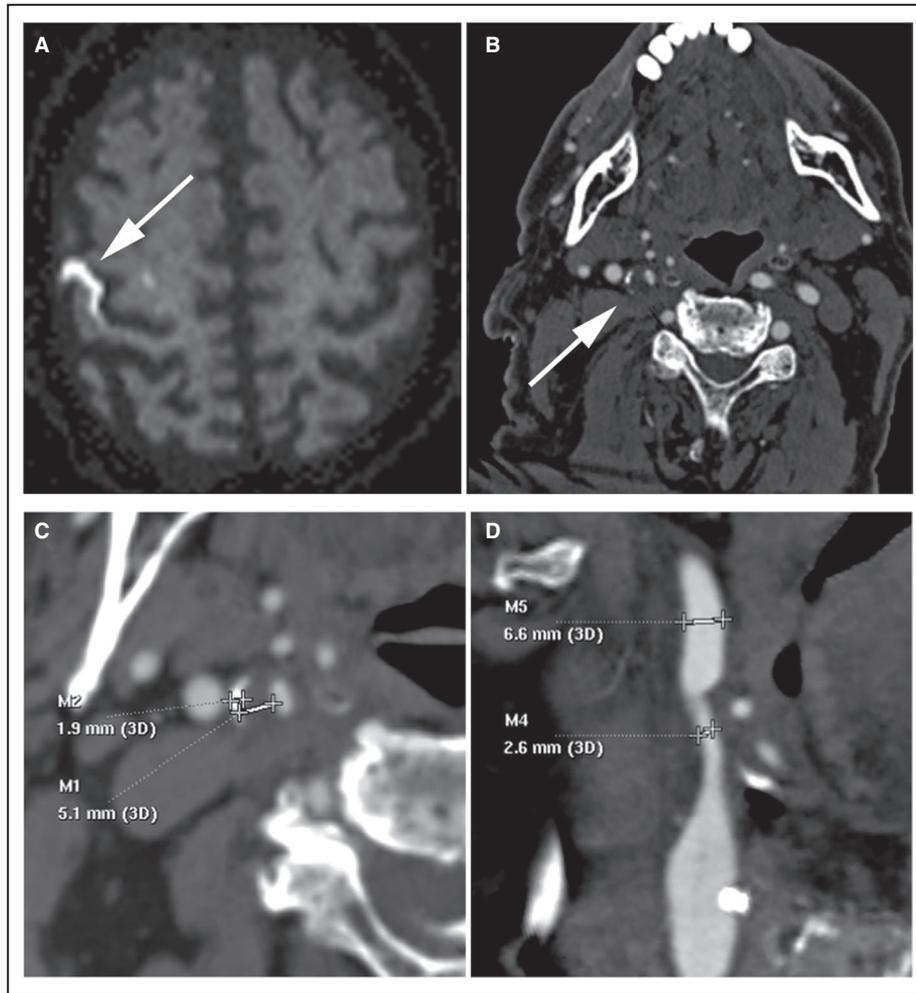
Computed tomography (CT) angiography carotid imaging markers and stroke workup.
